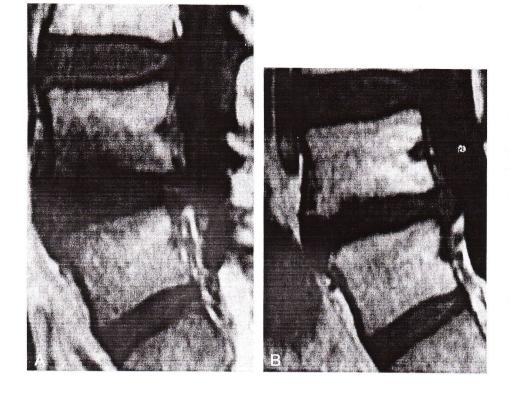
Change from Modic Type 1 signal (A) to Modic 0 signal (B) after arthrodesis in a patient with disc disease after L5–S1 discectomy caudal to a junctional anomaly (T1-weighted sequences).
